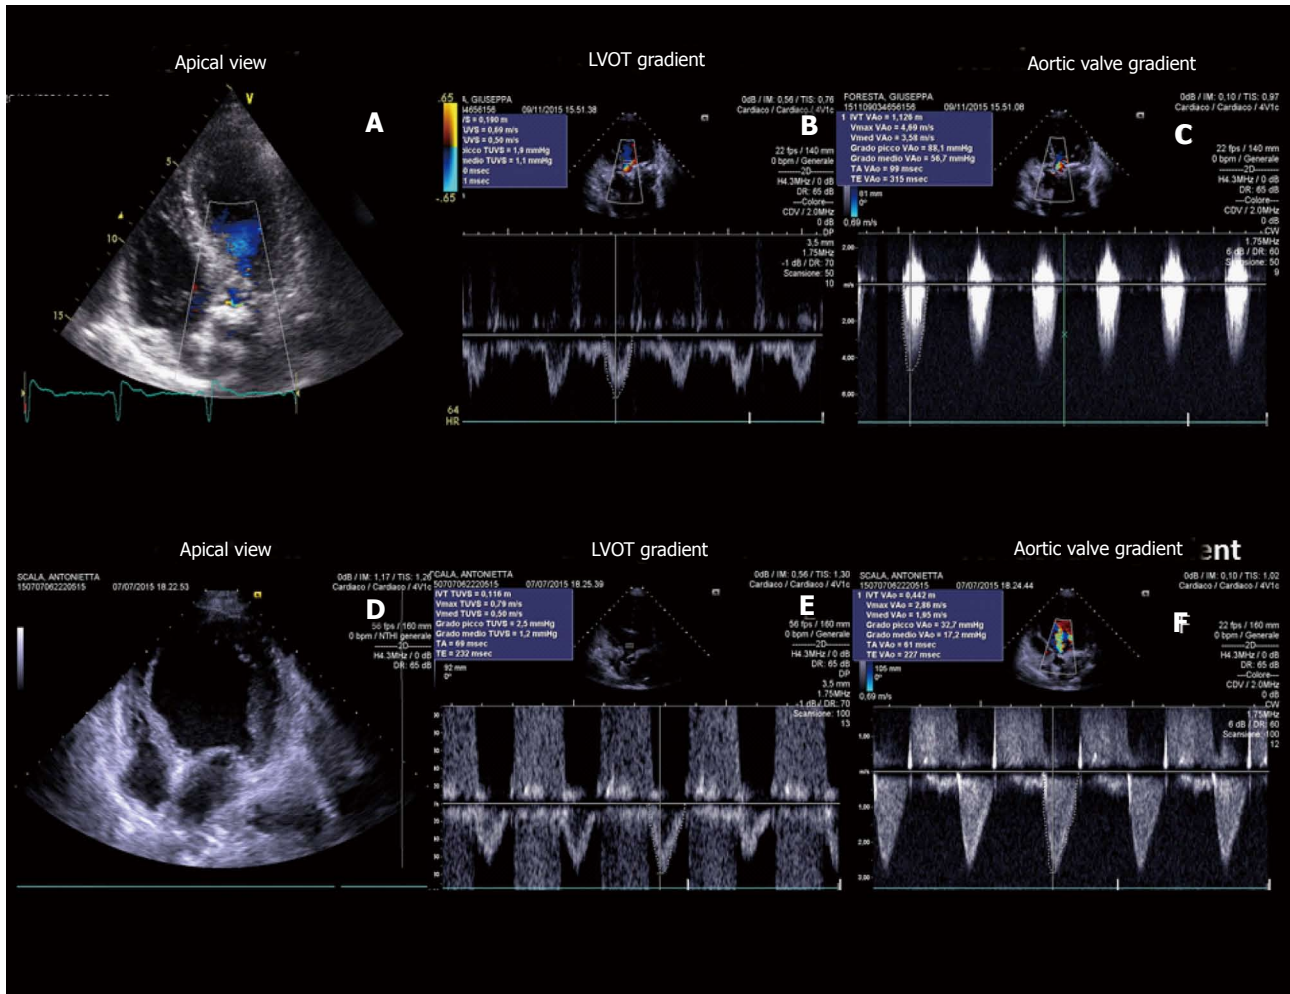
Transthoracic echocardiography gives detailed anatomic description of aortic valve complex and allows to estimate with enough reliability the haemodynamic entity of valvular stenosis by assessment of functional aortic valve area, derived using continuity equation. Two examples of severe aortic stenosis with normal ejection fraction and gradients (A-C), and with classical "low flow-low gradient" pattern (D-F). LVOT: Left ventricular outflow tract.
